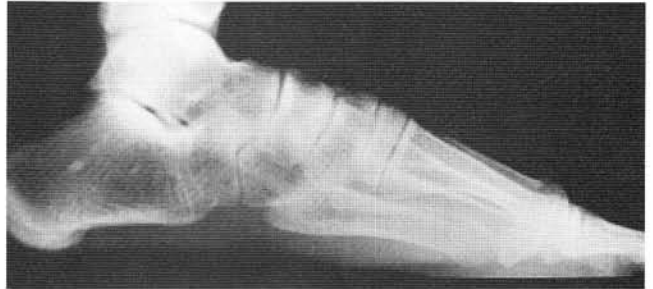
Preoperative lateral weight-bearing radiograph with hallux limitus and metatarsus primus elevatus.
